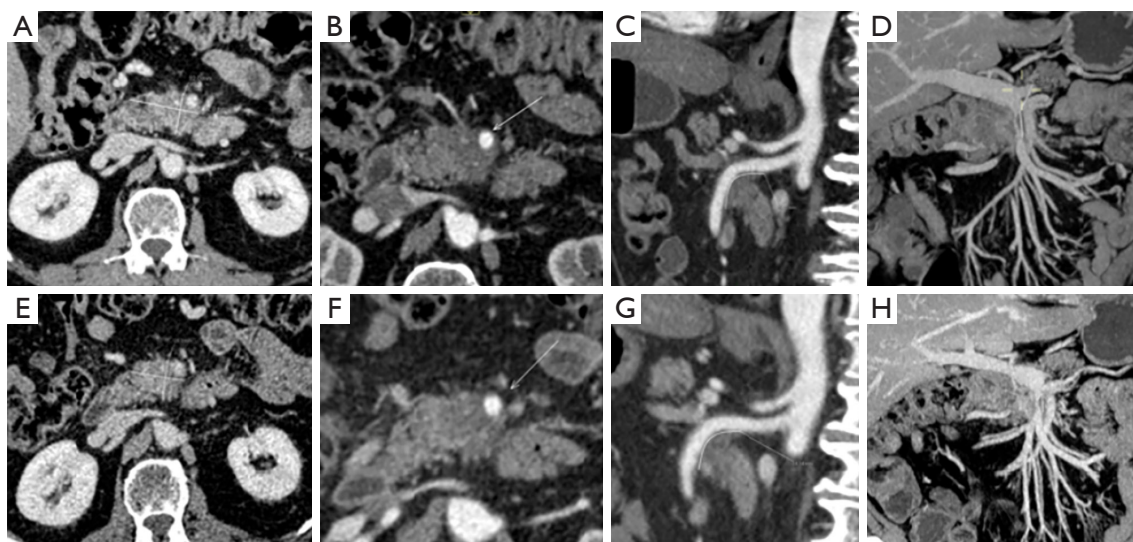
CT scan displaying a (A) biopsy-proven adenocarcinoma of the pancreatic head (52 mm × 32 mm); (B) radiologic evidence of >180° tumor interface to superior mesenteric artery, (C) extending for about 4 cm, and (D) signs of venous occlusion affecting the distal III of the superior mesenteric vein, for about 2.5 cm, suggesting the presence of an unresectable lesion. CT scan performed after 3 months from neoadjuvant chemoradiation showing (E) reduction (43 mm × 28 mm) of the lesion, (F) the presence of <180° tumor interface to superior mesenteric artery (arrow), extending for about 34 mm (G) and (H) the decrease of the extension of venous occlusion, feature of *borderline resectable* cancer. CT, computed tomography.
